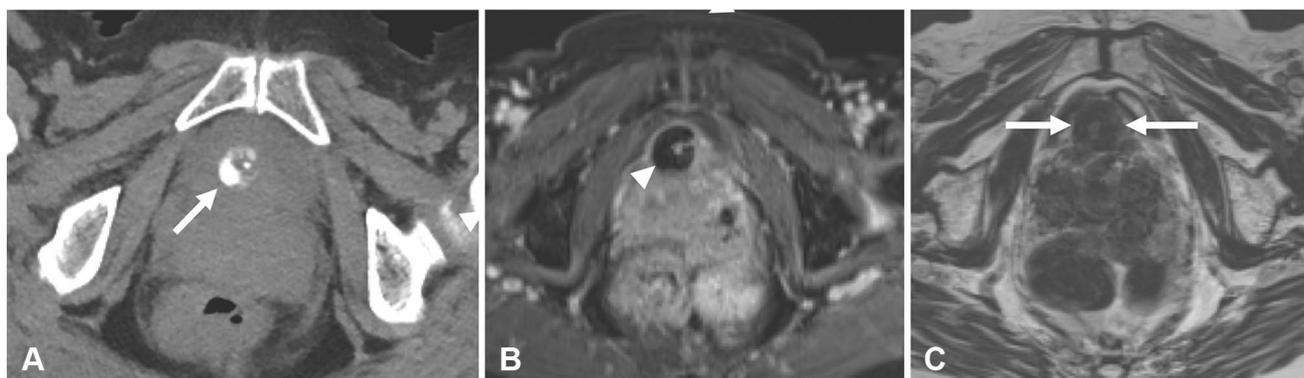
Periurethral carbon-coated bead injection on CT and MRI. 62-years-old female who was a poor surgical candidate underwent collagen injection into the submucosal layer of the urethra. a CT demonstrates dense material wrapping around the urethra (arrow), more compatible with carbon injection than collagen. b Axial
